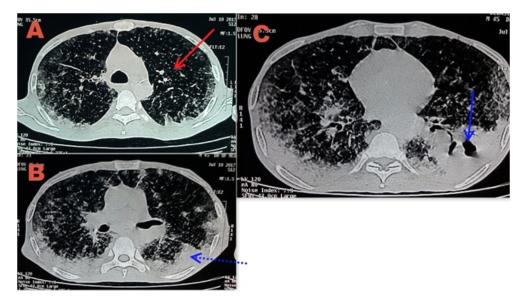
HRCT thorax of the patient showing nodular infiltrates in upper lobes (A; red arrow), peripheral consolidations in lower lobes (B, dotted line) and cavitation (C; blue solid line)
